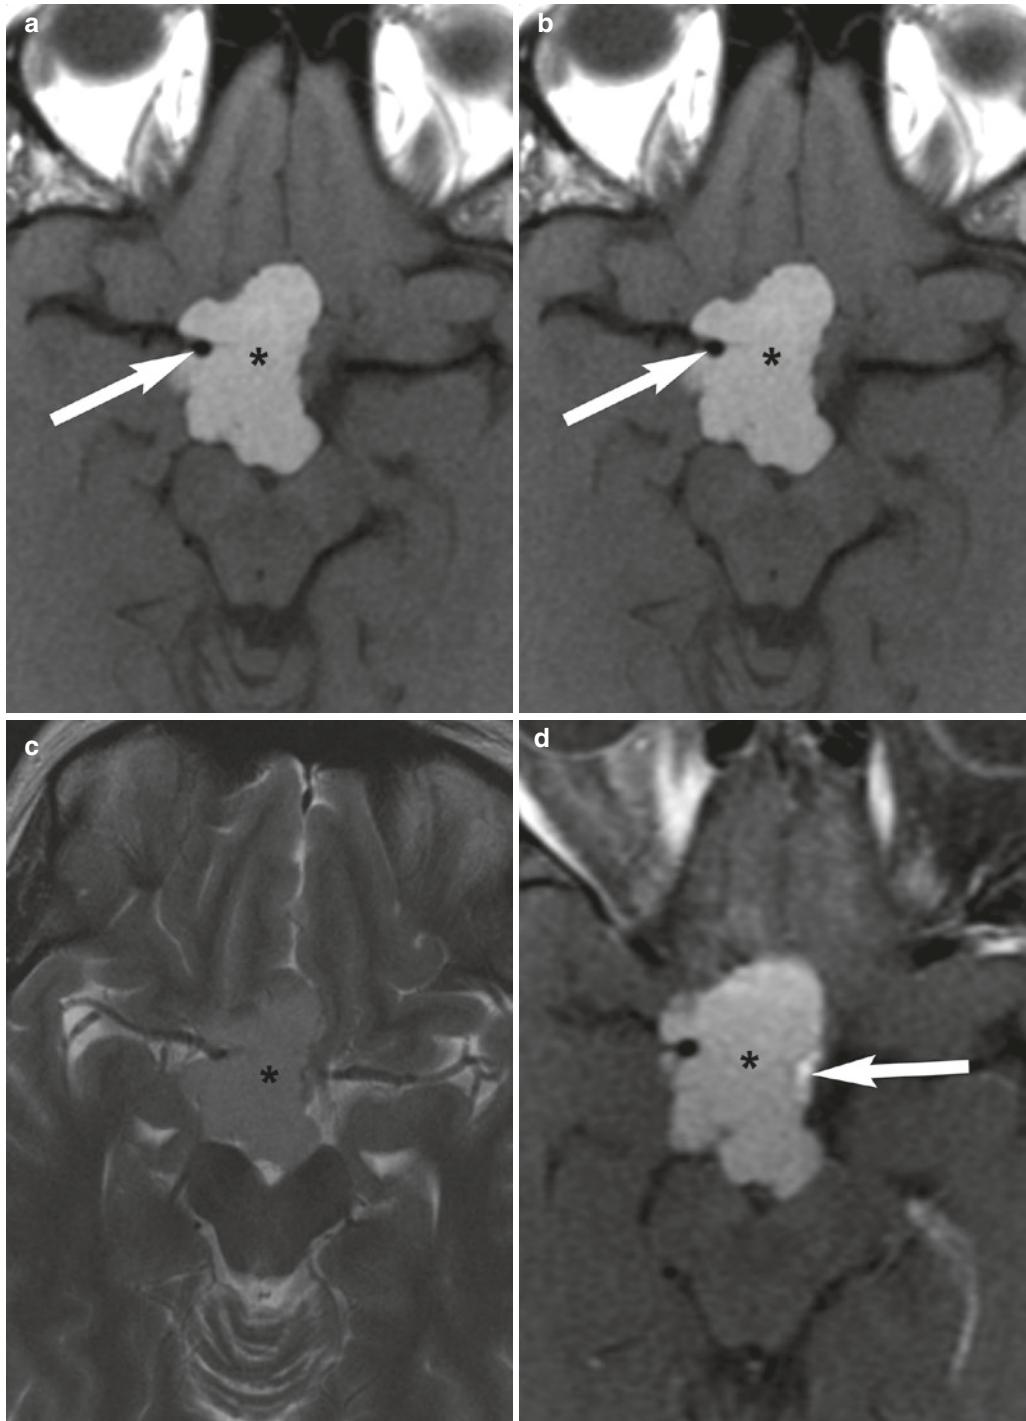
Craniopharyngioma, adamantinomatous. A 15-year-old male with altered mental status. Sagittal (a) and axial (b) unenhanced T1-weighted and axial unenhanced T2-weighted images (c) show lobulated suprasellar mass (*) which is hyperintense on T1-weighted
